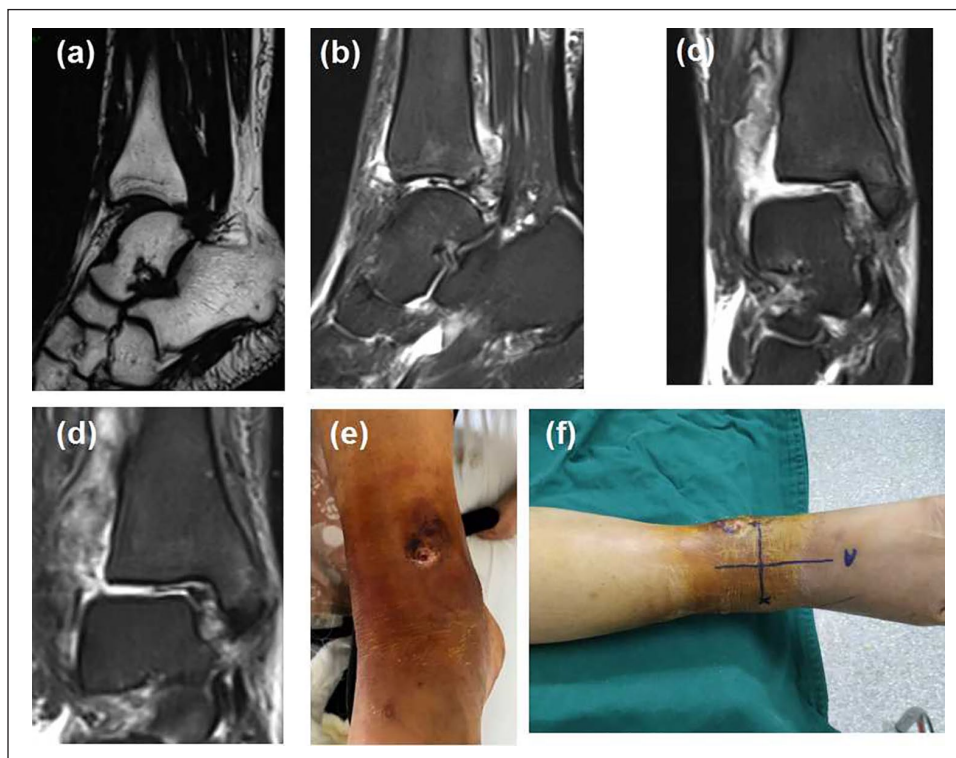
Preoperative MRI images and a cured infectious wound on the anteromedial region of the ankle. (a) Posterior subluxation of the talus on a sagittal view of MRI. (b–d) Loose osteochondral fragments in the tibiotalar joint on both coronal and sagittal view of MRI, and the rupture of the deltoid ligament on coronal view of MRI. (e, f) A cured infectious wound on the anteromedial region of the ankle.
